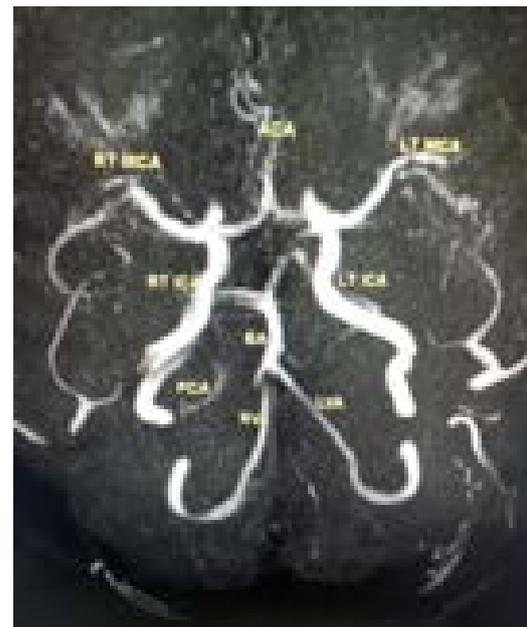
Normal Circle of Willis (MRI)
